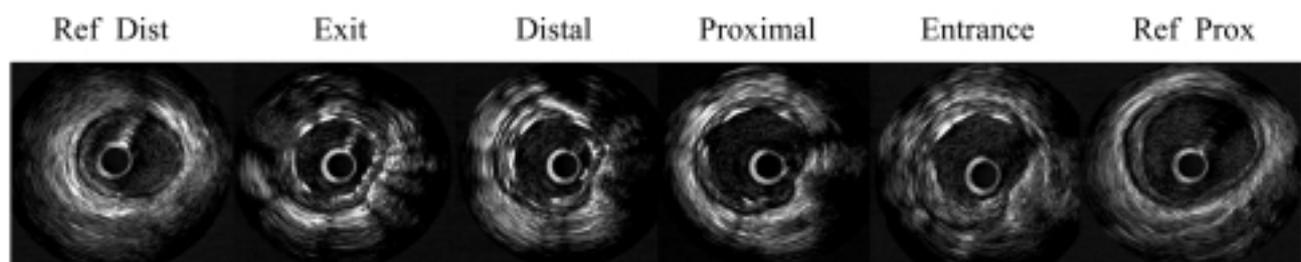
Six-month intravascular ultrasound multiple cross-sections of the sirolimus-eluting stent in the RAVEL trial, showing uniform absence of neointima proliferation.
